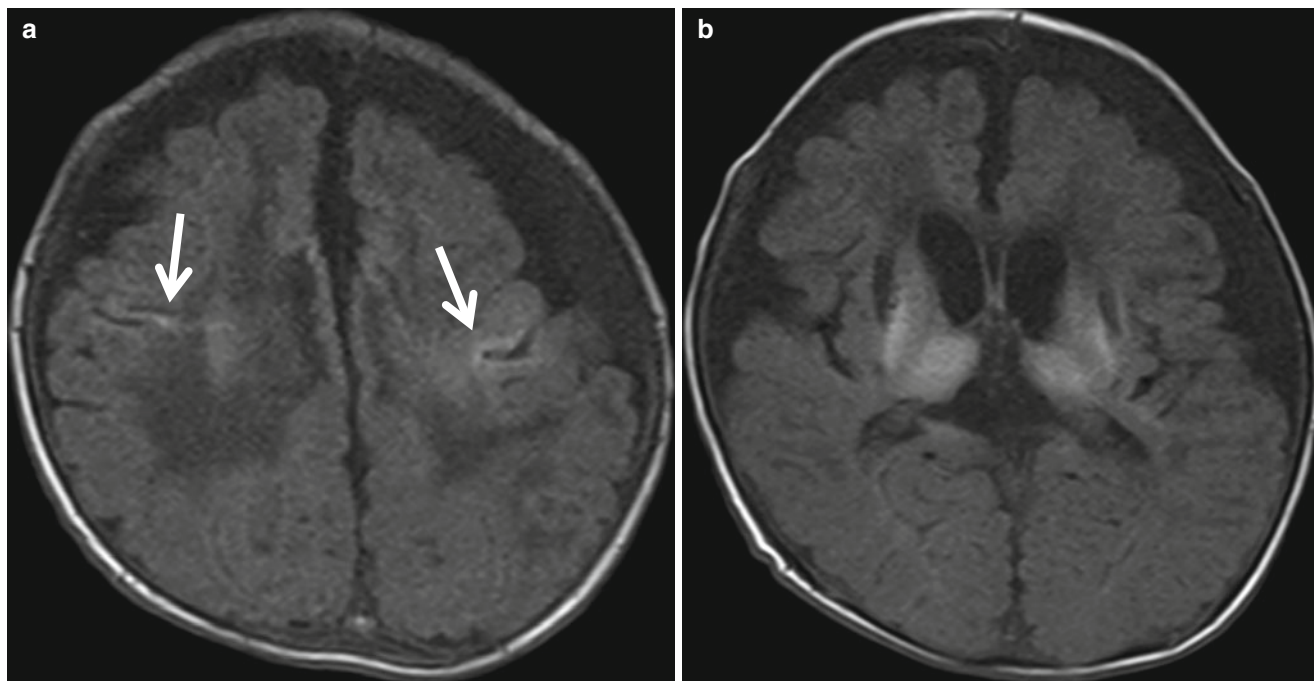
Neonate born after 37 weeks of gestational period and placenta abruption. (a–c) Serial T1-weighted images demonstrate hyperintense lesions in the sensorimotor cortex (*arrows in a*), lateral thalami, basal ganglia, hippocampi (*arrows in c*), and brain stem, associated with volume loss. (d) Markedly decreased signal intensity in thalami
